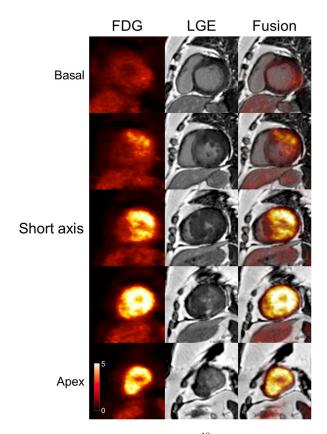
Serial short-axis images of ¹⁸F-fluorodeoxyglucose PET/MRI. ¹⁸F-fluorodeoxyglucose (FDG), late gadolinium enhancement (LGE), and fusion images from base (*upper*) to apex (*lower*).
